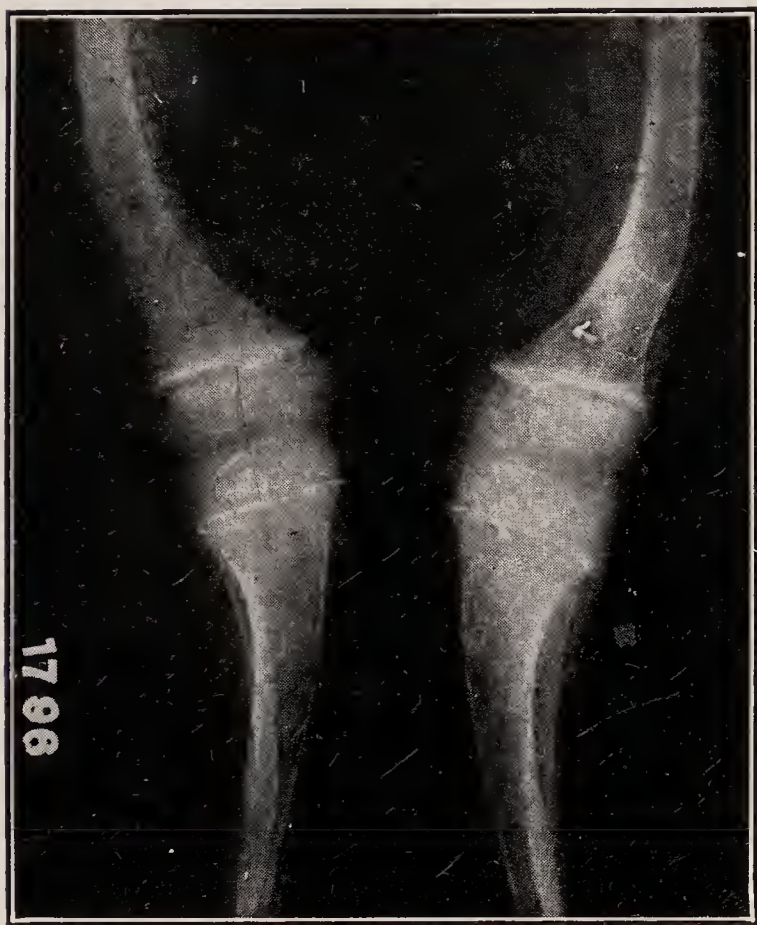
X-ray of healed rickets, showing white line.
